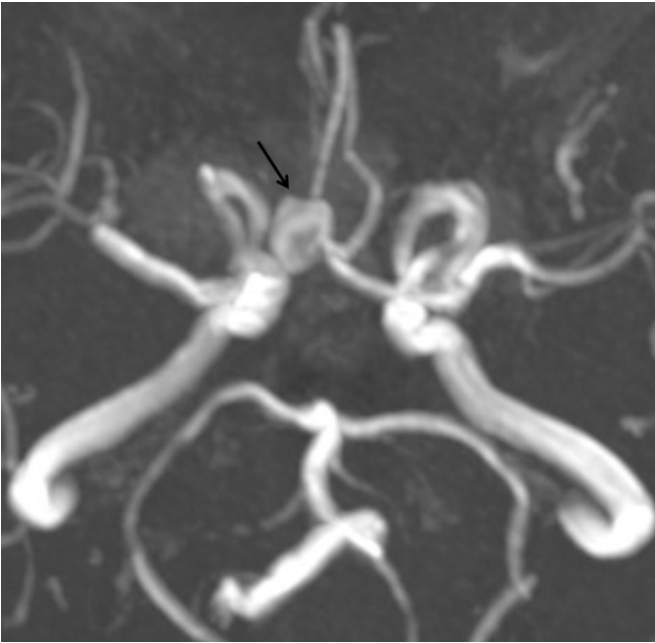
Time-of-flight magnetic resonance image of the most common variant (type 1) with an AComA aneurysm (black arrow).
